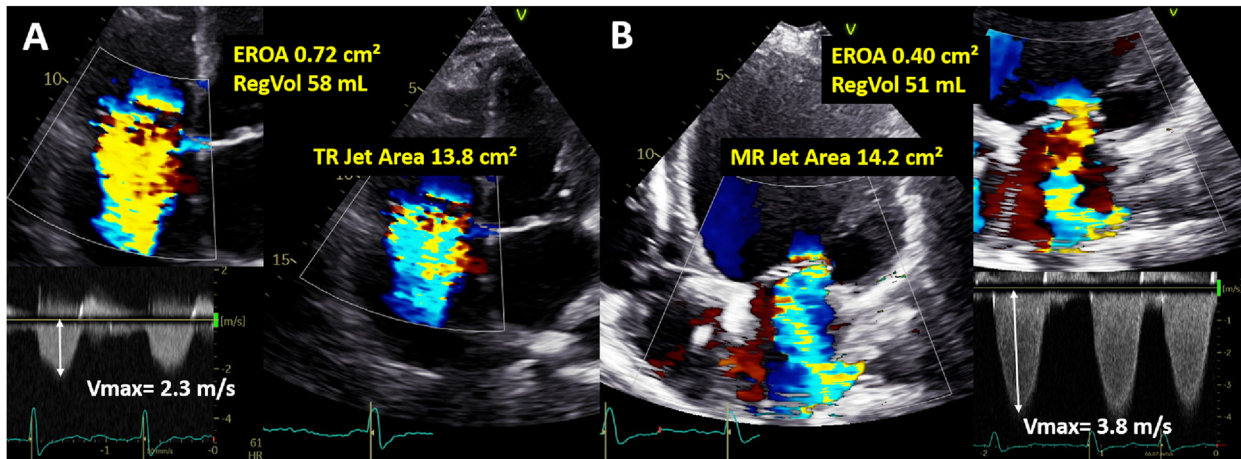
The relationship between tricuspid regurgitant orifice size and the expansion of the jet into the right atrium is governed by the conservation of momentum (M), which is proportional to the product of EROA and the square of jet velocity (v^2). In these cases, although the color flow jet area was comparable for the mitral and the tricuspid regurgitant jets (13.8 vs 14.2 cm²), the patient with TR (A) displayed larger EROA (0.72 vs 0.40 cm²) and RegVol (58 vs 51 mL) compared with the patient with mitral regurgitation (MR; B). These differences arose mainly from the lower velocity of the TR jet (2.3 vs 3.8 m/s). *MR*, Mitral regurgitation; *Vmax*, maximal regurgitant jet velocity on continuous-wave Doppler.
